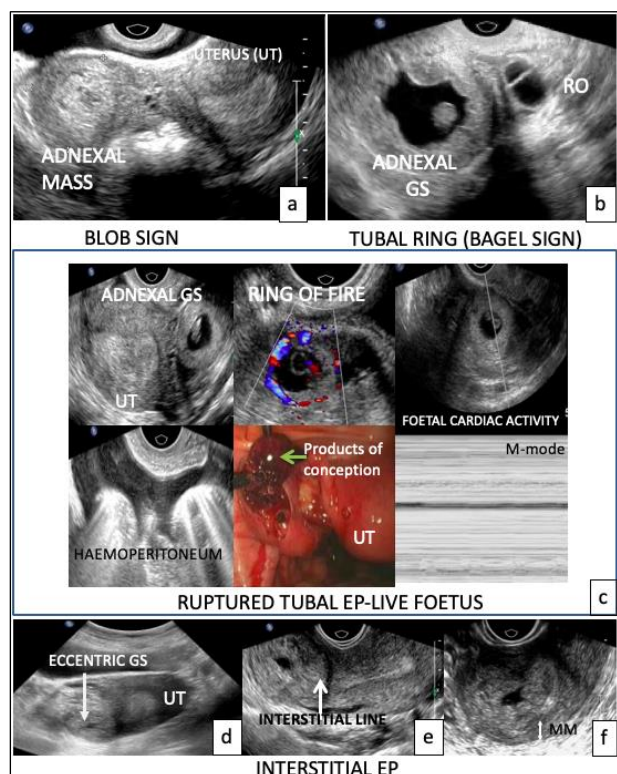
Sonographic findings in tubal EP. a) Heteroechoic right adnexal mass (Blob sign). UT-uterus. b) Echogenic ring surrounding right adnexal gestational sac (GS) adjacent to the right ovary (RO)-Tubal Ring (Bagel Sign). c) Ruptured EP showing right adnexal GS with live foetus, pelvic free fluid with echoes (haemoperitoneum). Intraoperative findings show ruptured tube with products of conception. d,e,f) Interstitial EP showing eccentrically located GS outside endometrial cavity with interstitial line sign and thin surrounding myometrial mantle (MM).
